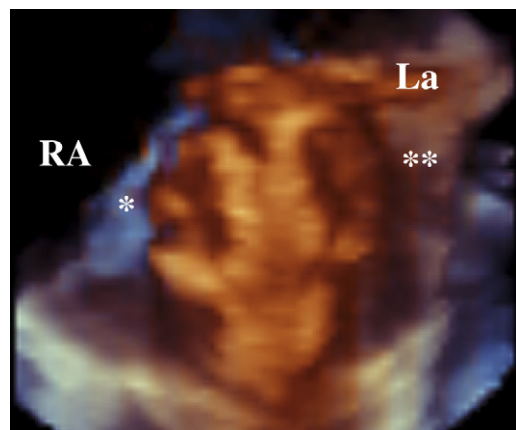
A 3D echocardiographic image demonstrating the relationship of the right (*) and left (*) atrial discs of an Amplatzer device (AGA Medical, Plymouth, MN) used to close a secundum atrial septal defect. *Abbreviations:* RA, right atrium; LA, left atrium).
